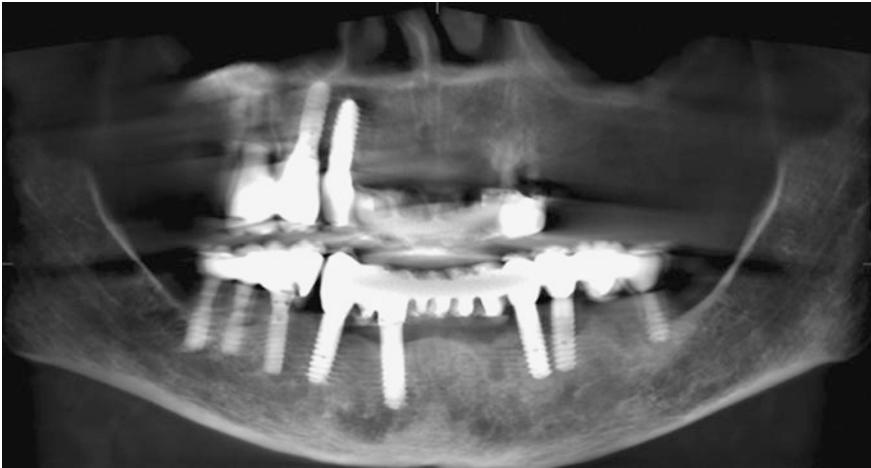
CBCT pre-operative panorex shows the left edentulous maxilla
